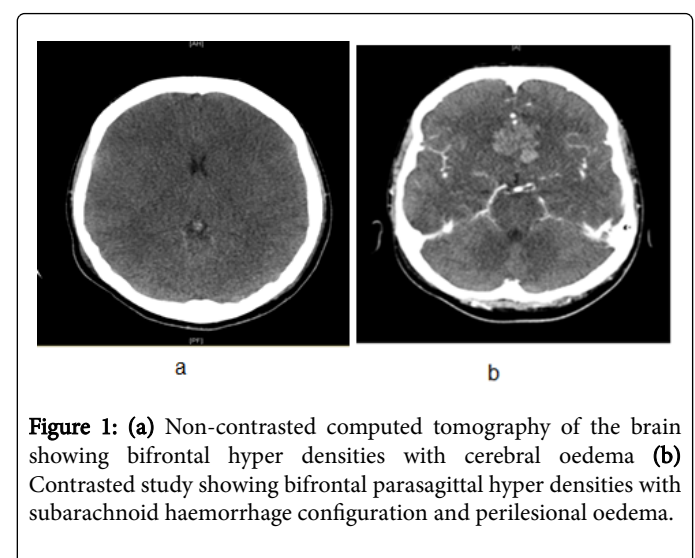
(a) Non-contrasted computed tomography of the brain showing bifrontal hyper densities with cerebral oedema (b) Contrast study showing bifrontal parasagittal hyper densities with subarachnoid haemorrhage configuration and perilesional oedema.
